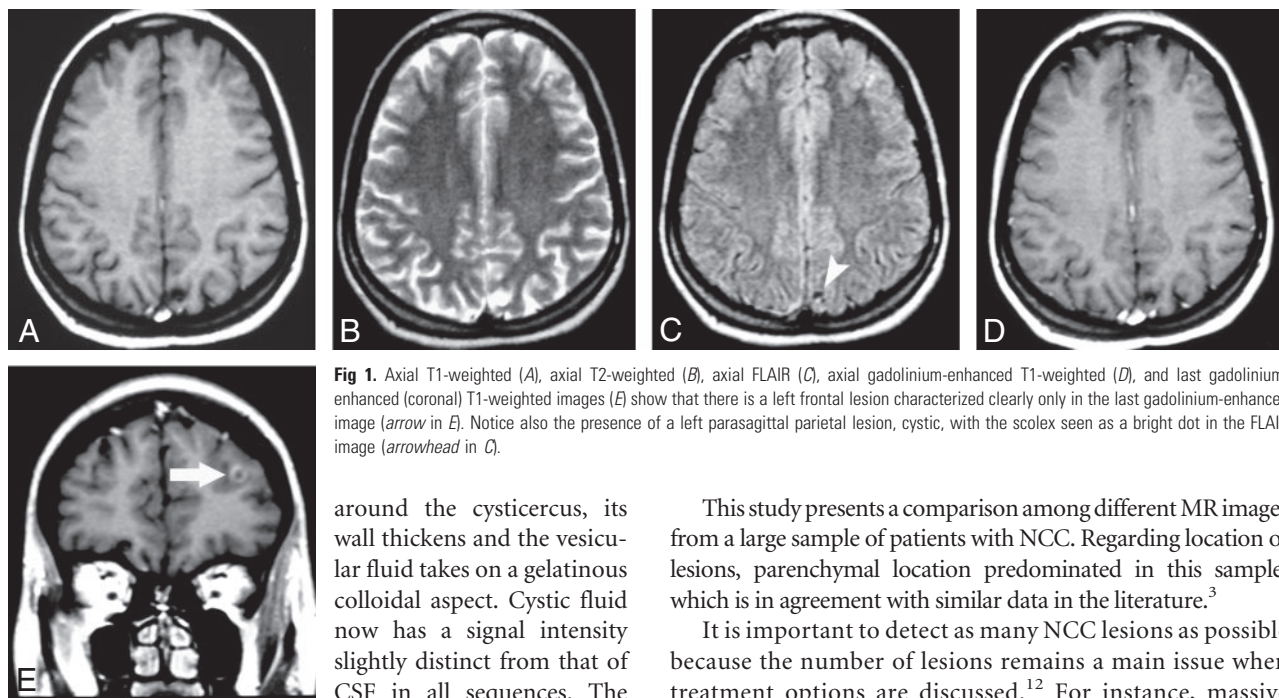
Axial T1-weighted (A), axial T2-weighted (B), axial FLAIR (C), axial gadolinium-enhanced T1-weighted (D), and last gadolinium-enhanced (coronal) T1-weighted images (E) show that there is a left frontal lesion characterized clearly only in the last gadolinium-enhanced image (arrow in E). Notice also the presence of a left parasagittal parietal lesion, cystic, with the scolex seen as a bright dot in the FLAIR image (arrowhead in C).
